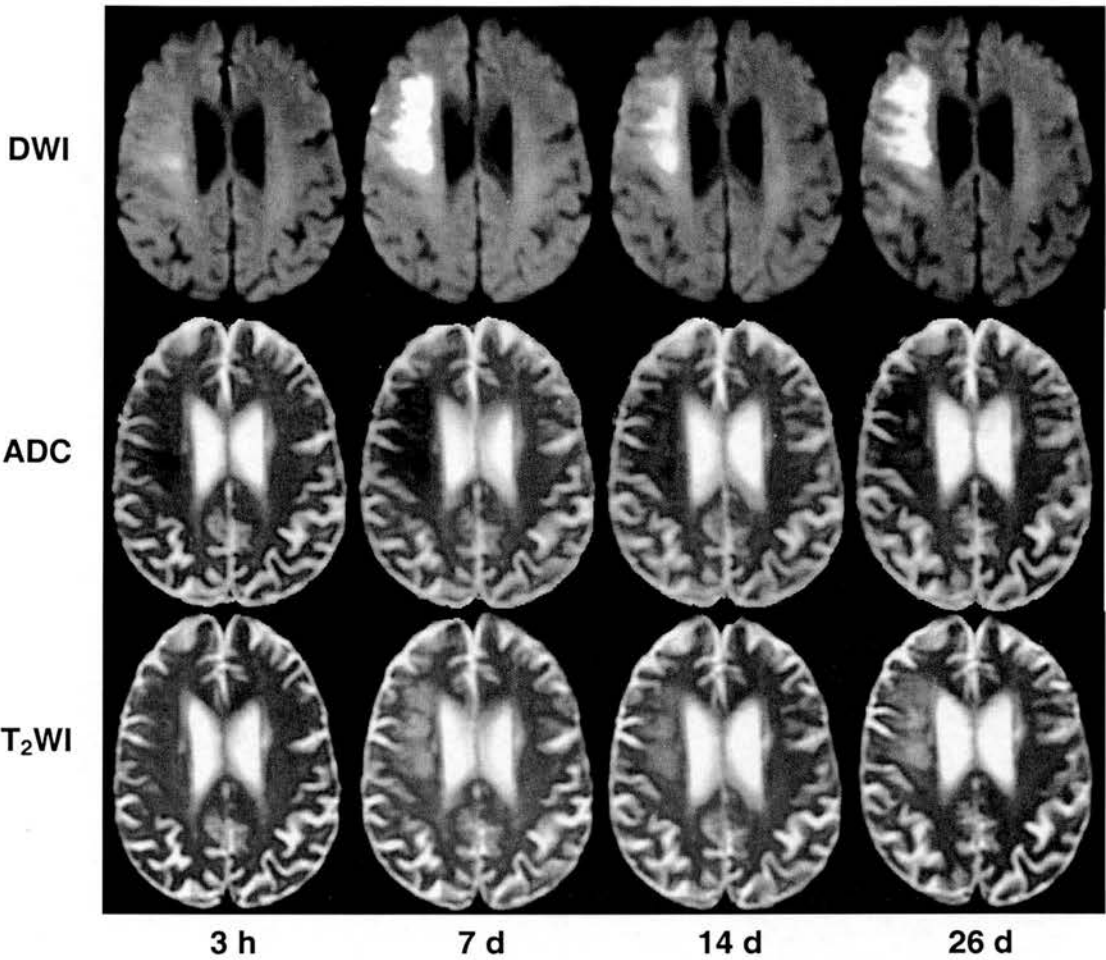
DWI, ADC, and T₂WI of a patient with a right hemisphere ischaemic lesion from baseline to 26 days after stroke onset. Note the lesion on DWI has a region of persistent hyperintensity at 26 days after stroke onset, corresponding with a region of hypointensity on the ADC image.
